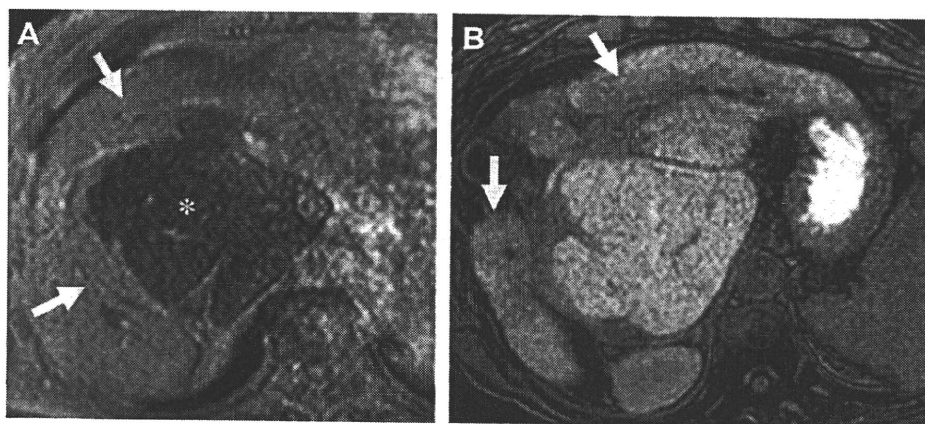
T2-weighted GRE image (TE, 9.5 ms) within 10 minutes after administration of SPIO (A) demonstrates a high-intensity area in which SPIO particles are not taken up, presenting fibrotic change and hepatocyte damage (arrows). Conversely, uptake of SPIO particles is observed in the caudate lobe (asterisk). T1-weighted fat-saturated 3-dimensional (3D) gradient-echo (GRE) images (TR/TE = 3.6/1.7 ms, flip angle = 15°) in hepatocyte-selective phase (B) shows also decrease of uptake of Gd-EOB-DTPA (arrows). (Same patient as in Fig. 4.)
